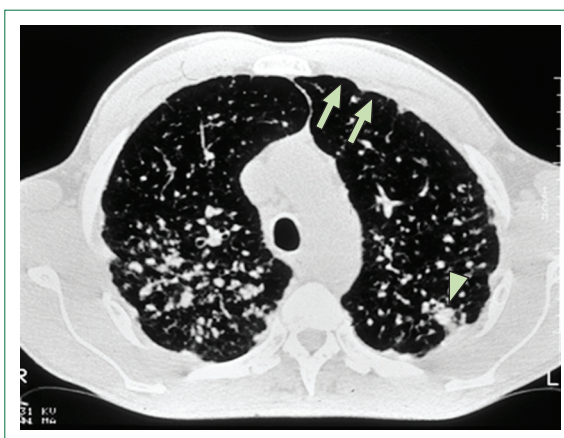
CT scan showing silicosis in a man from the UK who dug tunnels for a living. The scan shows pleural involvement (arrows) and confluence of opacity (arrow head).
